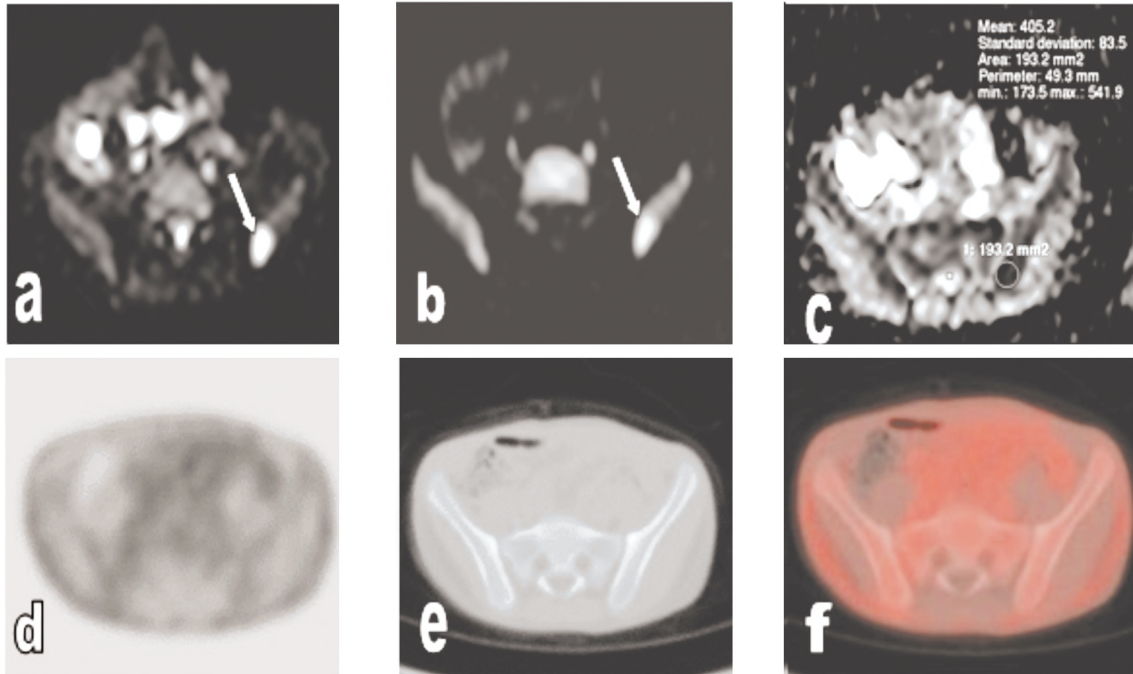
Axial PET-CT versus Axial DWIBS images for the same patient: (A,B,C): Axial b0 DWI (A), b1000 DWI (B), ADC₃ map (C). Demonstrating restricted diffusion at left iliac osseous lymphomatous lesion (arrows). ADC = 0.405 x10 mm²/sec. (D,E,F): Axial PET (D), CT bone window (E) and Fused PET-CT (F) Images showing non visualization of the left iliac lesion with no related focal increased FDG uptake.
